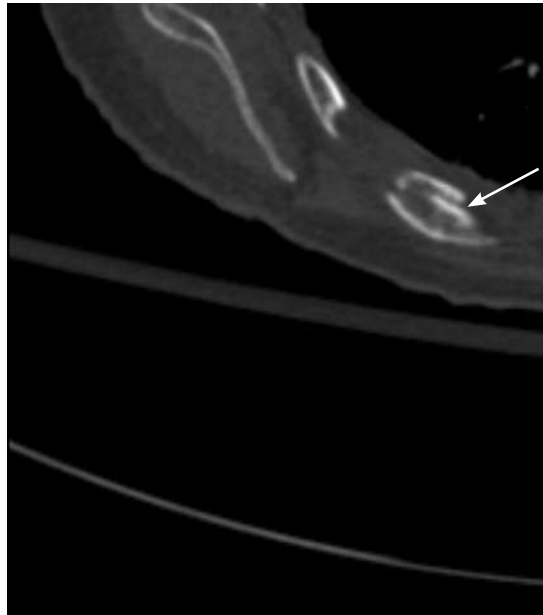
Computed tomographic scan (zoomed axial image) shows an acute rib fracture.
